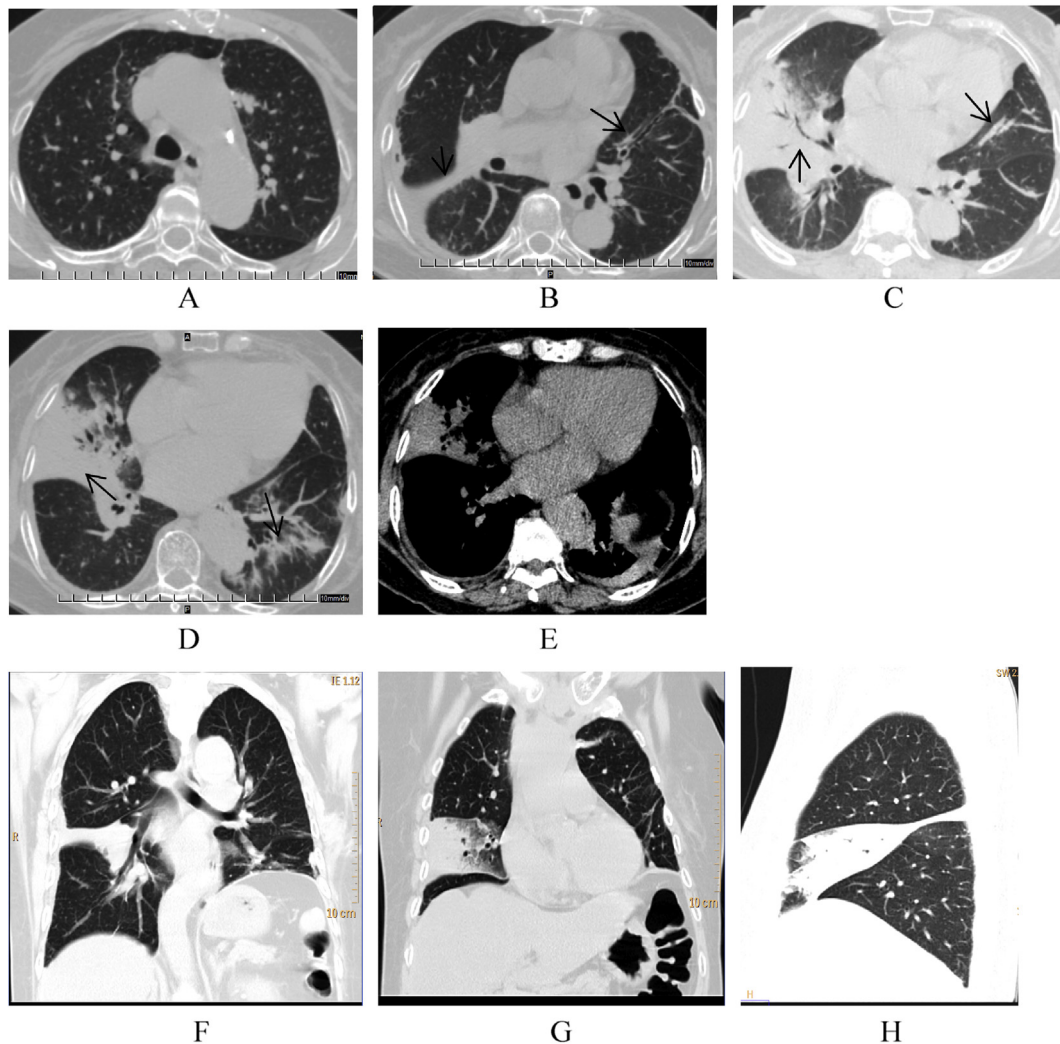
(A–G). Chest CT scanning on Dec 1, 2013 (the 4th day after onset). A: A patch of high-density opacity at the left upper lung lobe near the aortic arch. B: The right interlobar effusion and pleural effusion in a small quantity, dilated bronchi at the left upper lung, and thickened interlobular septum (indicated by arrow). C: A large flake of consolidation opacity at the right middle lung lobe with air bronchogram, thickened interlobular septum at the left upper lung which was predominantly posterior to the interlobular fissure of the left lung (indicated by arrow). D: Consolidation opacity at the right middle lung lobe, patch of ground glass opacity at the dorsal segment of the left lower lung lobe. E: Intrapulmonary effusion of the left lung in a small quantity. F: Coronal image revealed obviously thickened right transverse fissure and right pleura. G: Coronal image showed consolidation opacity at the right middle lung lobe, which was peripherally obvious. H: Sagittal view image demonstrated co-existence of consolidation opacity at the right middle lung lobe and interlobar effusion.
